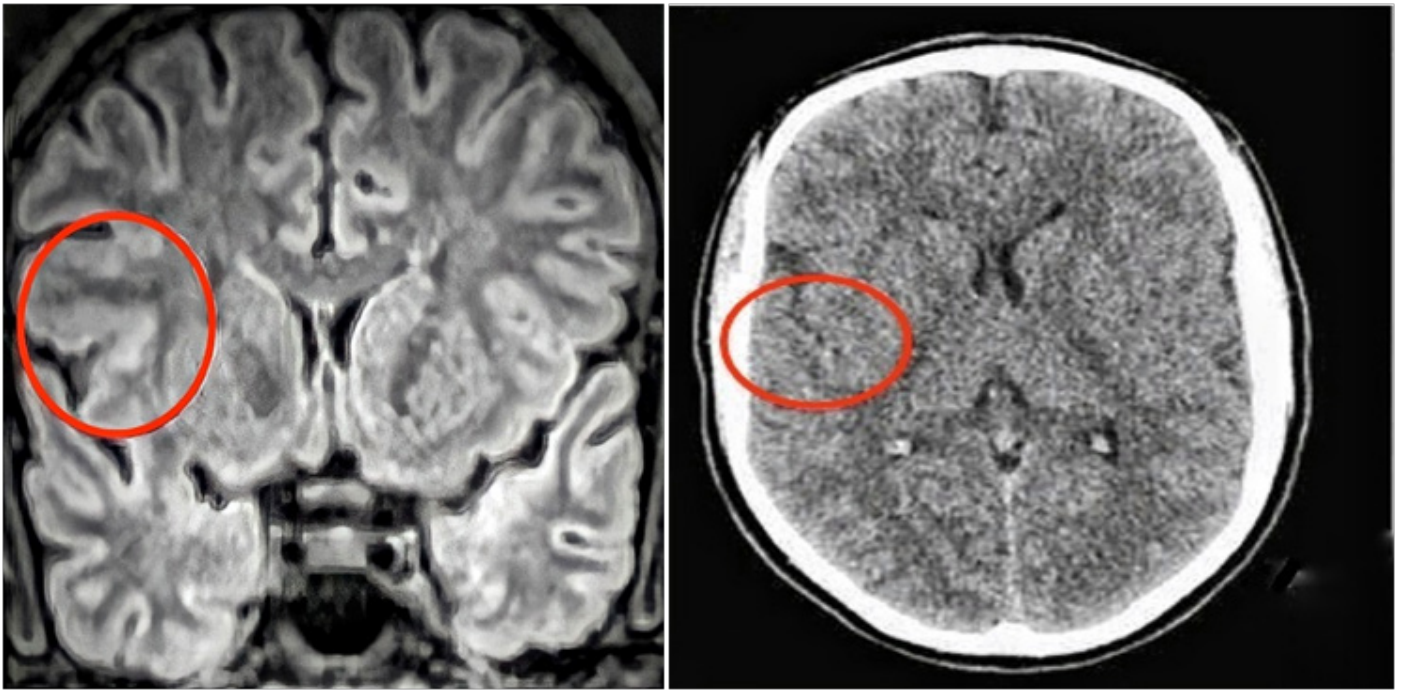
MRI and CT scans disclosed focal cerebral abnormalities
